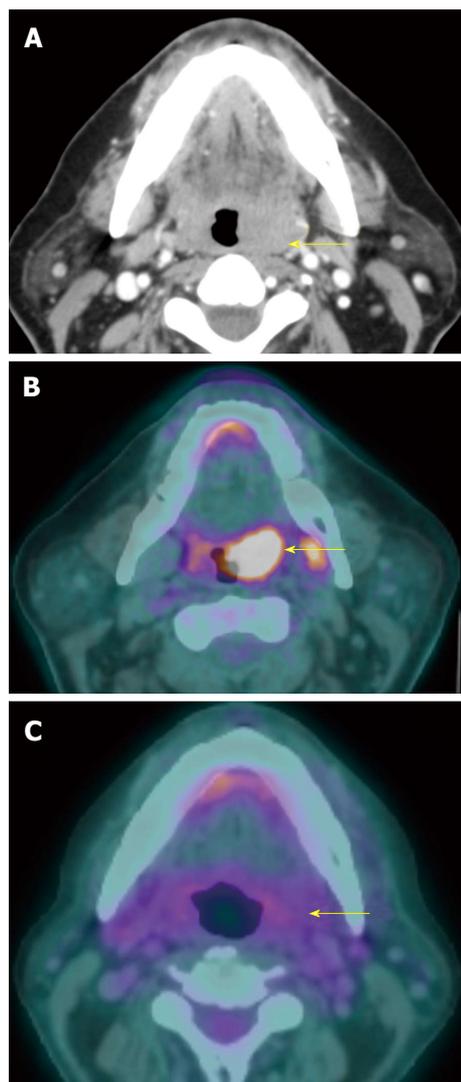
Complete treatment response at the primary tumor site. A T2N0M0 oral tongue squamous cell carcinoma (yellow arrow) seen on contrast-enhanced computed tomography (CT) (A) and positron emission tomography/CT (PET/CT) (B) showed complete response after 3 mo of chemoradiation demonstrated on PET/CT (C). The tumor is no longer hypermetabolic. The patients remained disease free for 3 years, proving true negative result of PET/CT.
